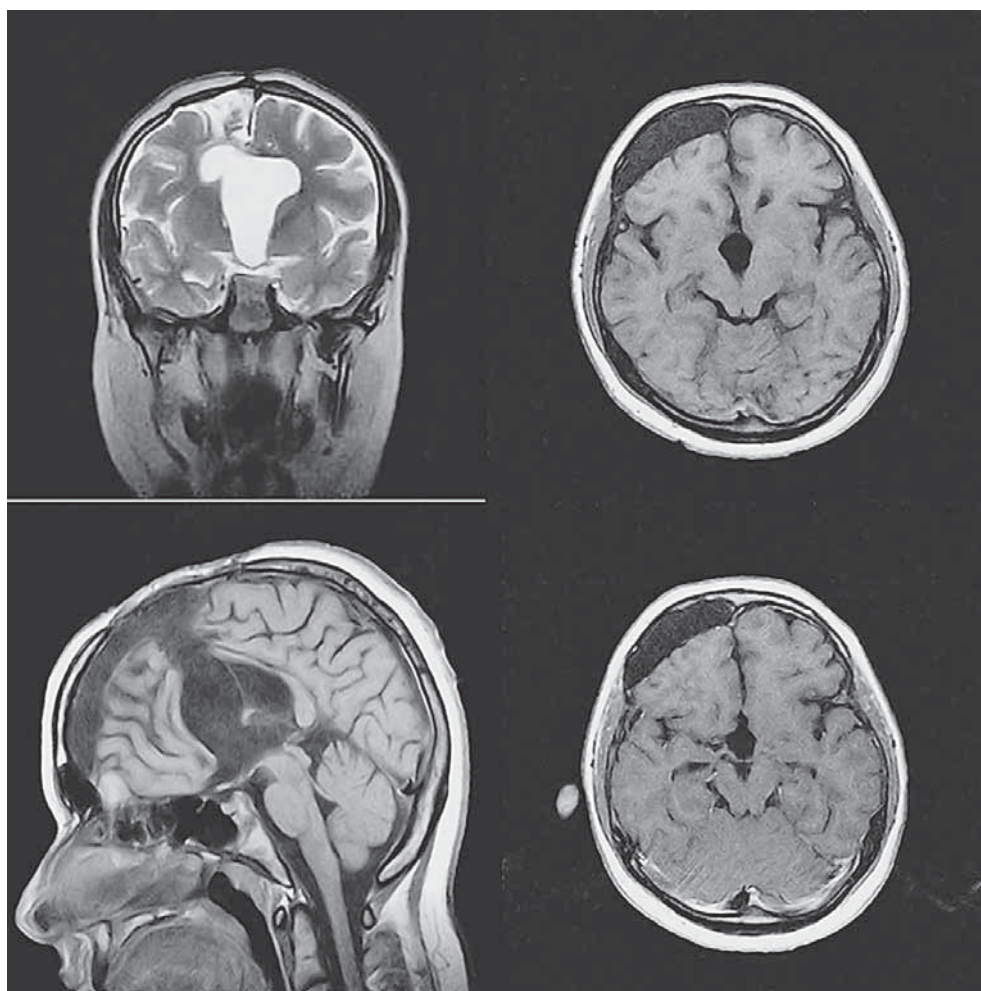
MRI acquired 14 months after the operation showing complete tumor removal and no signs of tumor recurrence.
